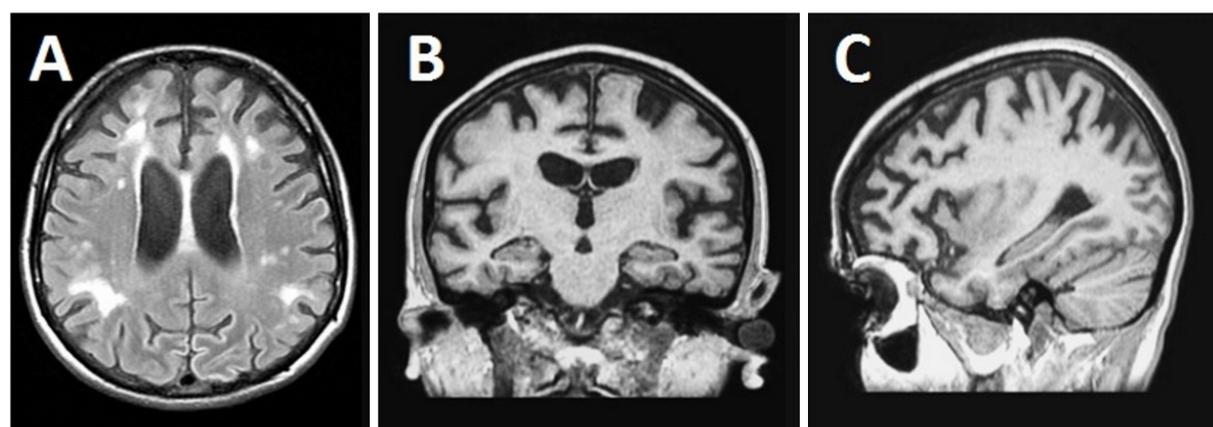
Brain magnetic resonance imaging of case 6. Axial fluid-attenuated inversion recovery image (A) showing white matter hyperintensities; coronal (B) and sagittal (C) T1 images reveal atrophy in frontal and parietal lobes (with some degree of left predominance) and preservation of the hippocampus
